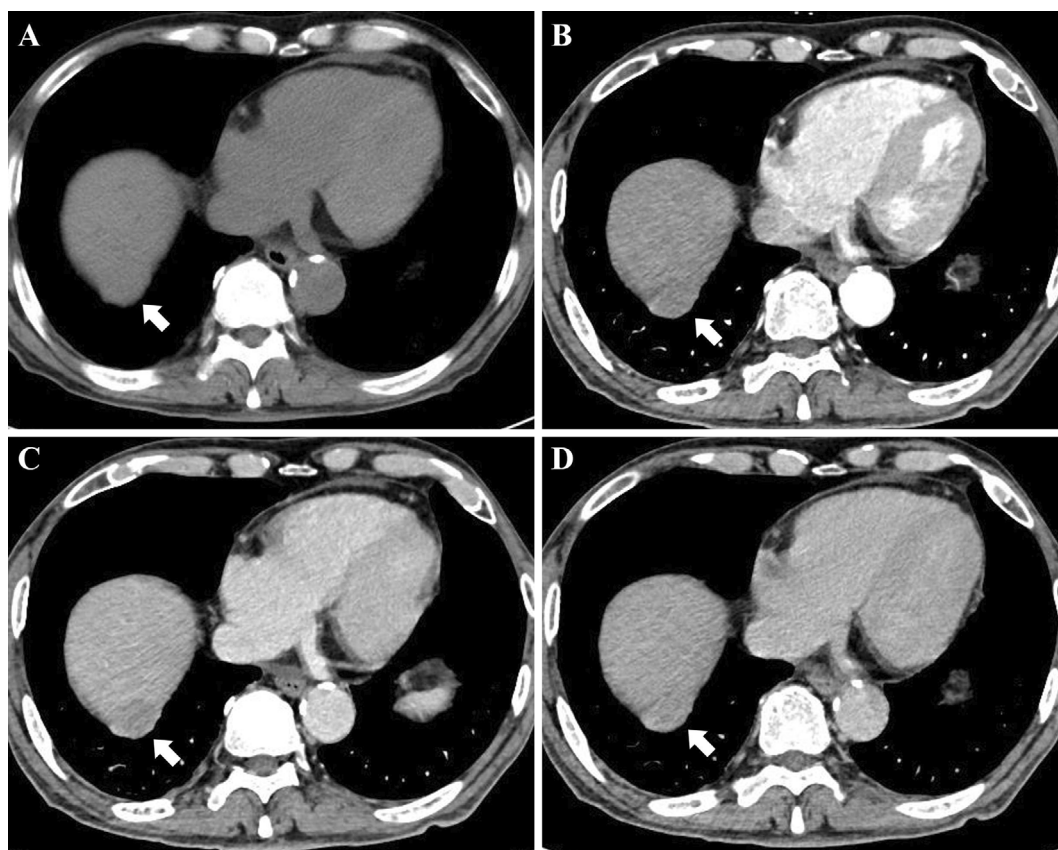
Dynamic CT findings of the tumor in 2017. The tumor was slightly enhanced in the early phase and showed prolonged enhancement in the portal and equilibrium phases. (A) Plain. (B) Early phase. (C) Portal phase. (D) Equilibrium phase. CT: computed tomography
